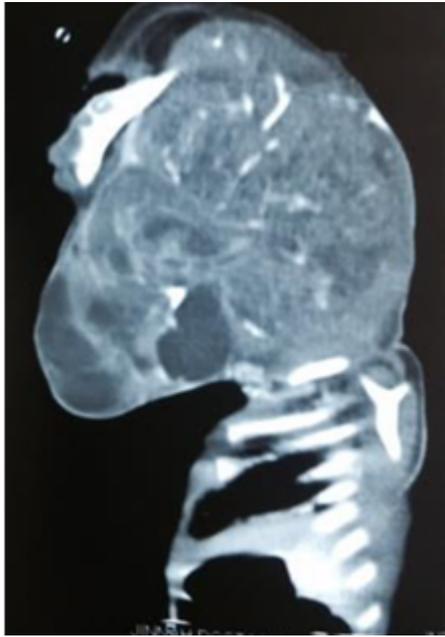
CT-scan head and neck showing heterogeneous mass with calcification
